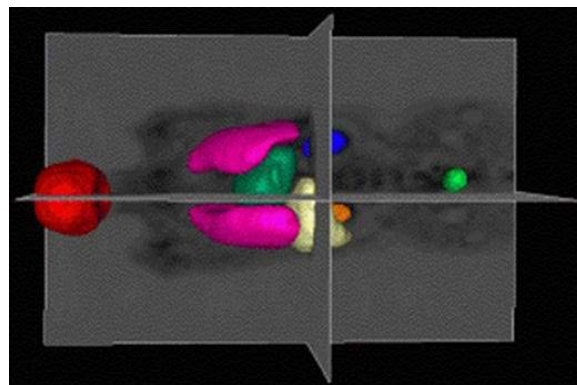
Automatic organ segmentation based on CT data which is overlaid on PET data for quantitative analysis.
